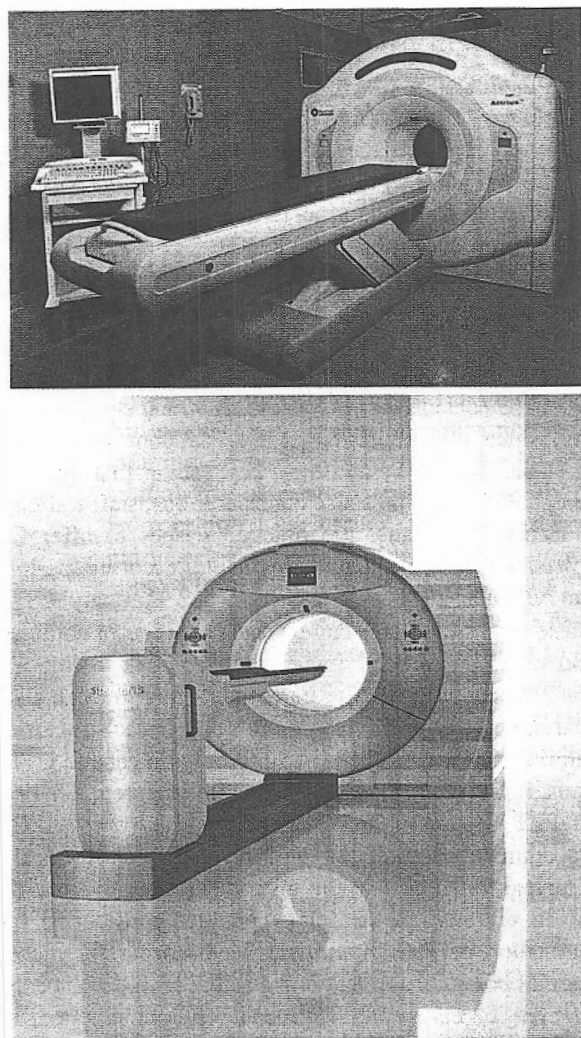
Examples of a PET-only system (*upper* Attrius by Positron) and a PET/CT system (*lower* Biograph mCT by Siemens). *Sources of photos:* upper Peter Webner, Positron; lower Nicole Webber, Siemens.
